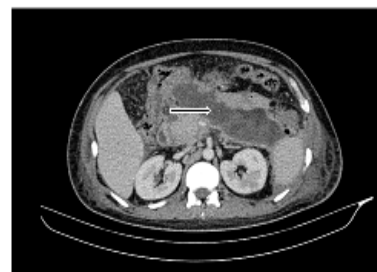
Axial image of contrast enhanced CT examination shows necrotic collections (arrow) as one of the complication of acute pancreatitis.
